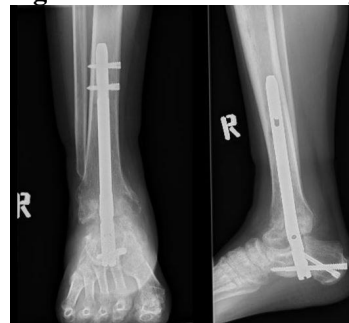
Post operative 5month x-ray
